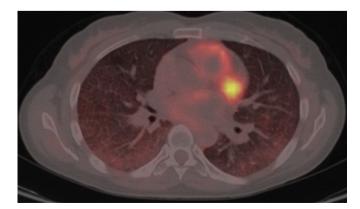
18F FDG PET/CT showing high uptake of fluorodeoxyglucose in the bilateral interstitial infiltrations.
